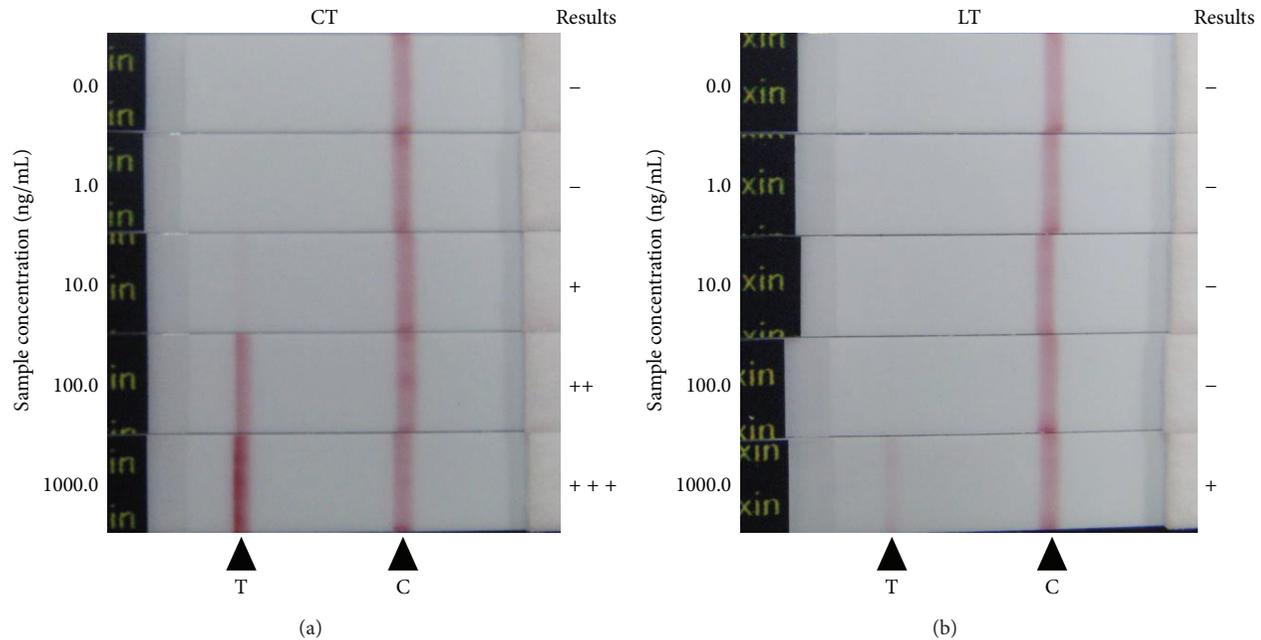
Reactivity of CT-IC with purified recombinant CT and LT. 0.1 mL of serial diluted purified recombinant CT (a) or LT (b) was applied to the test strips. After 15 minutes, development of red color at position for test (T) or control (C) lines was monitored. Concentrations of samples applied are indicated on right side of each strip. The “+++”, “++”, “+”, or “-” symbols are placed on the left side of the strips developing “strong”, “medium”, “faint”, or “no” bands at test lines, respectively.
